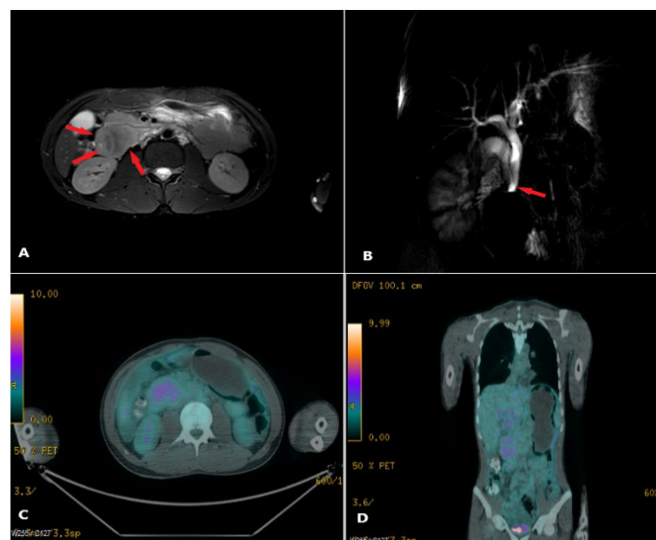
MRI and MRCP visualized a 3.8×3.5 cm mass lesion consistent with a tumor that was localized lateral to the pancreatic head and in the duodenal ampulla (A) and causing a sudden interruption in the choledochal duct and dilatation proximally (B).
